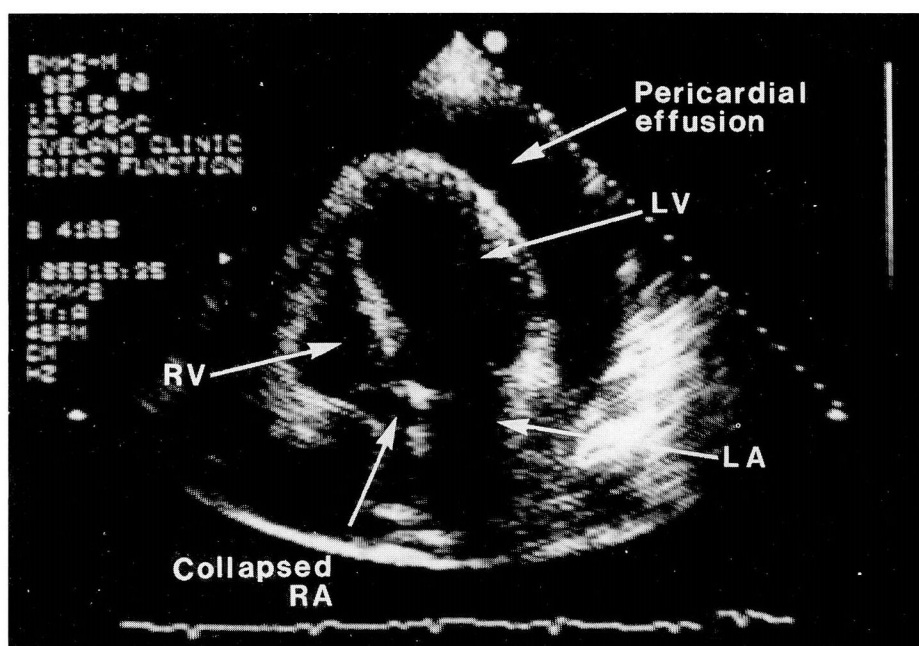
Apical four-chamber view of the heart showing a large pericardial effusion and diastolic collapse of the right atrium consistent with cardiac tamponade.
